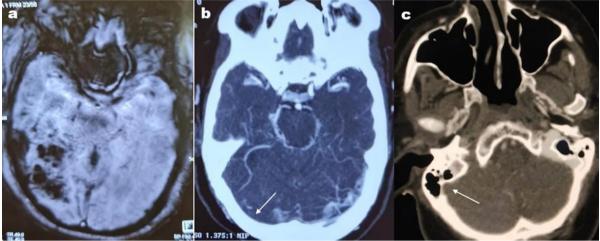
Magnetic resonance imaging showing intraparenchymal hemorrhage in the right temporo-parietal region[a]. CT angiography showing filling defect in [b]right transverse sinus(arrow) and right sigmoid sinus(arrow)[c].
